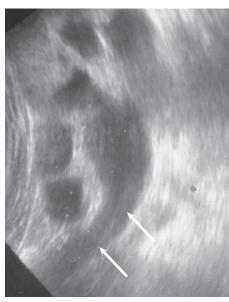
Renal ultrasound scan of a patient with obstruction of the urinary tract causing hydronephrosis. The kidney is hydronephrotic with dilation of the pelvicalyceal system; dilation of the upper ureter is also clearly seen (*arrows*).
